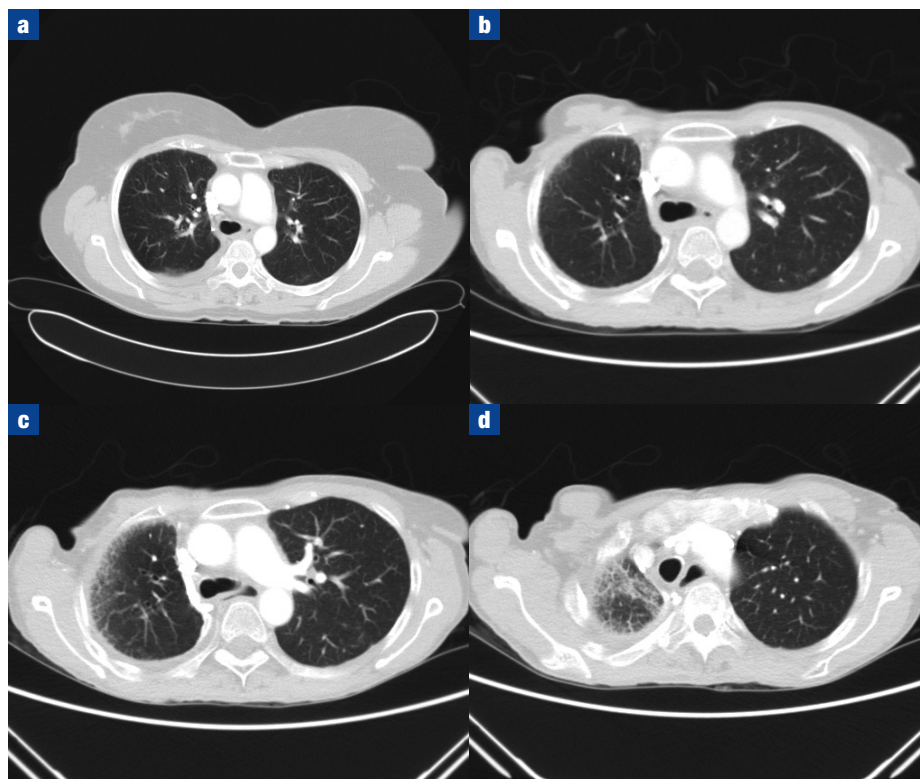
Serial chest imaging. Axial computed tomography images of the chest. Progression of the unilateral subpleural fibrotic changes is most evident at the periphery and apex of the right lung. a. February 2011. b. September 2013. c and d. October 2014.
